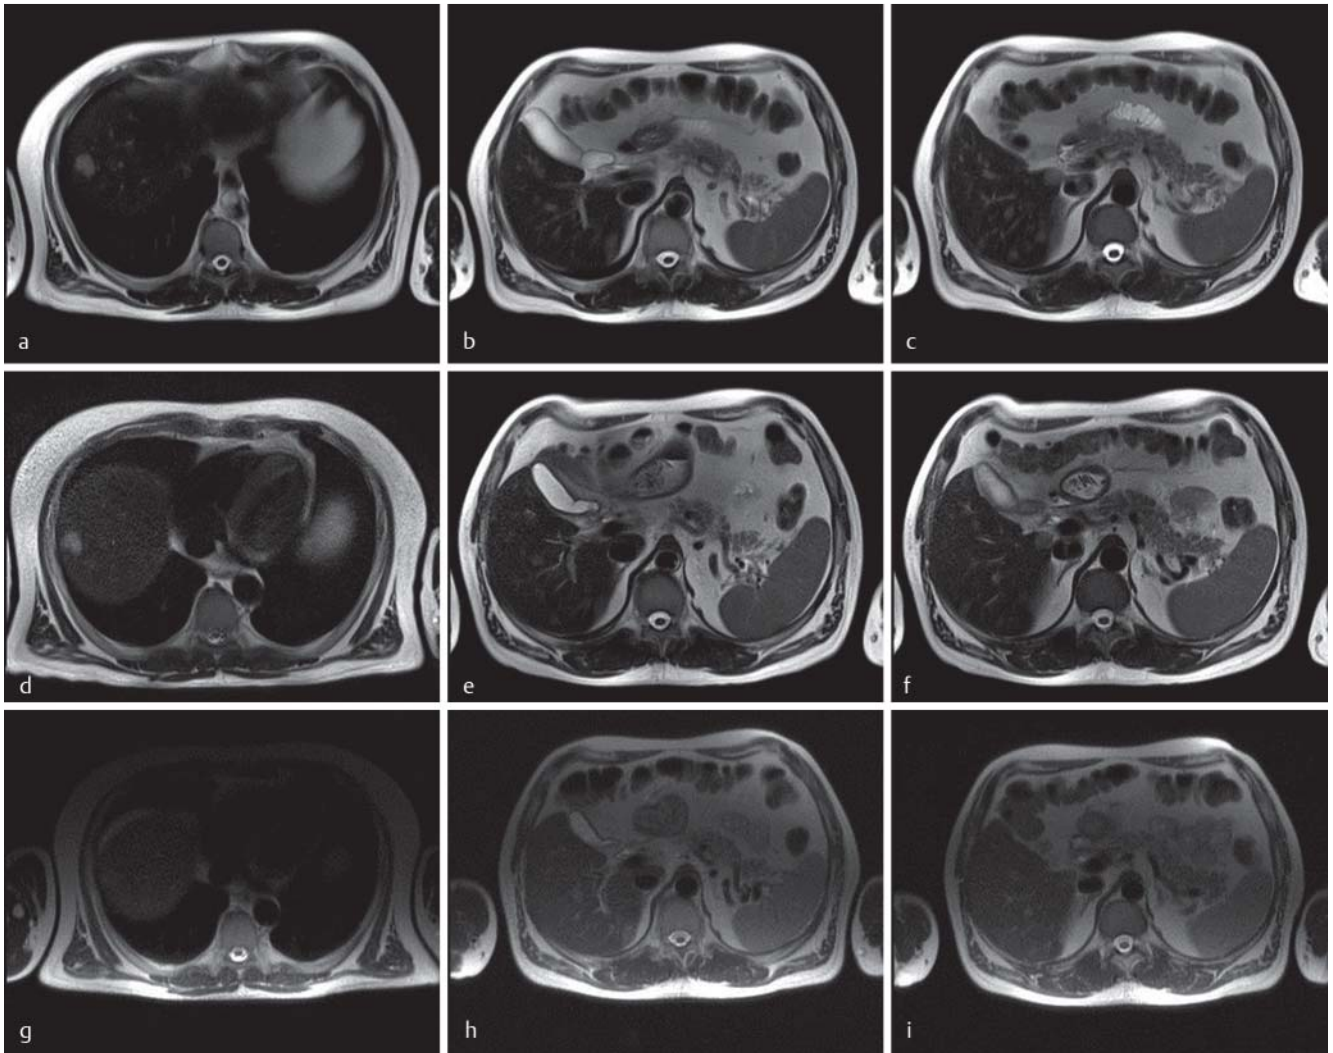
Magnetic resonance images (T2 haste) of the liver of a patient with ocular melanoma who was treated with chemosaturation-PHP with melphalan a–c. Stable disease of diffuse small metastases was observed 8 weeks after treatment d–f. Without any further therapy, the patient had a partial response in the liver 6 months after chemosaturation-PHP g–i.
